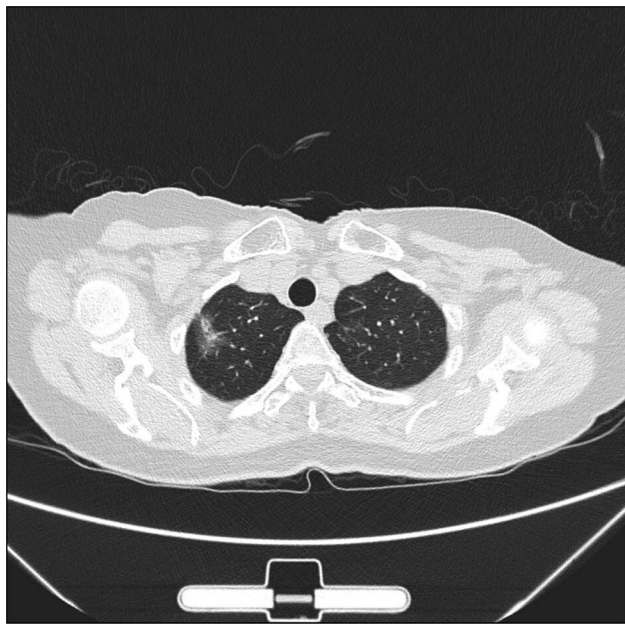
CT of the chest and mediastinum axial plane showing a 2.7-cm nodule at periphery of the right upper lung. CT, computed tomography.
